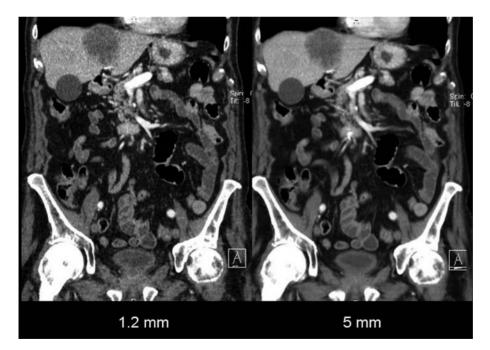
Enhanced standard-dose MDCT of the abdomen showing a liver metastasis in a man with prostate carcinoma. Left CT image is reconstructed in the coronal orientation with a thickness of 1.2 mm and shows quite an important mottle aspect of the abdominal structures. Right CT images is reconstructed in an identical orientation but with a thickness of 5 mm. The mottle aspect seen in the thin-section coronal CT slice is no longer visible. The effect of image smoothing by thickening the CT slice is seen when the noise is due to low-dose scanning and when the noise is related to high-frequency reconstruction algorithms
